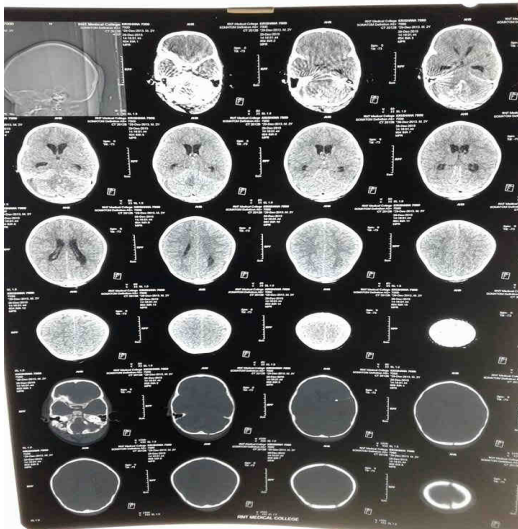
CT head showing cerebellar hematoma with SDH with occipital bone fracture
